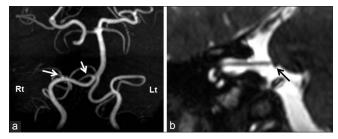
Case 2 (a) magnetic resonance angiography showing duplication of posterior inferior cerebellar artery (arrows) on the right side, (b) sagittal three-dimensional fast imaging with steady-state acquisition magnetic resonance imaging showing the artery (arrow) compressing the root exit zone
